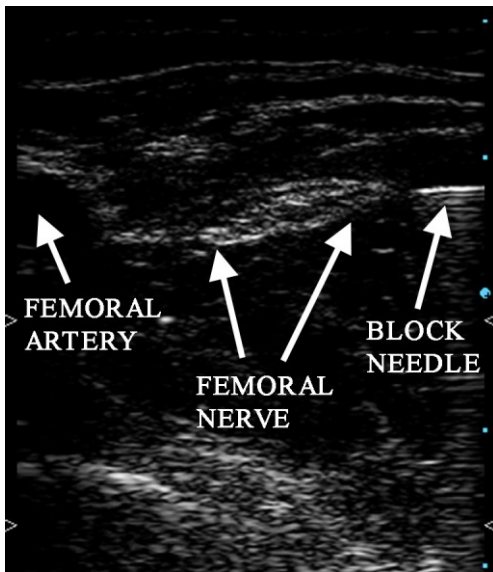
Sonogram of in plane perpendicular approach to the femoral nerve.
